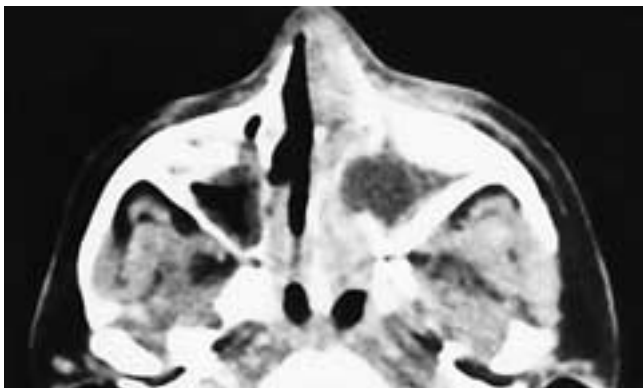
Axial contrast-enhanced CT scan shows a mucoid attenuation polypoid mass in the left maxillary sinus that bulges into the left nasal fossa. Inflammatory mucosal changes are seen in both nasal fossae, and there is enhancement of the mucosa around the polyp. This patient had an antrochoanal polyp.
